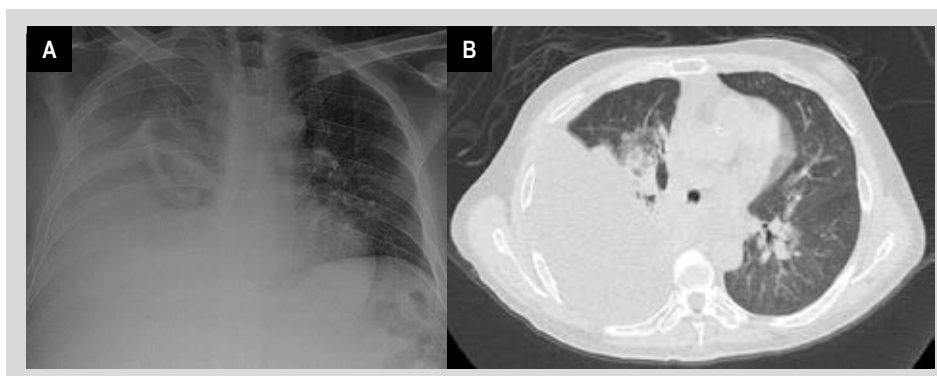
Massive right pleural effusion in (A) chest X-ray and (B) chest tomography of the first patient at admission.
